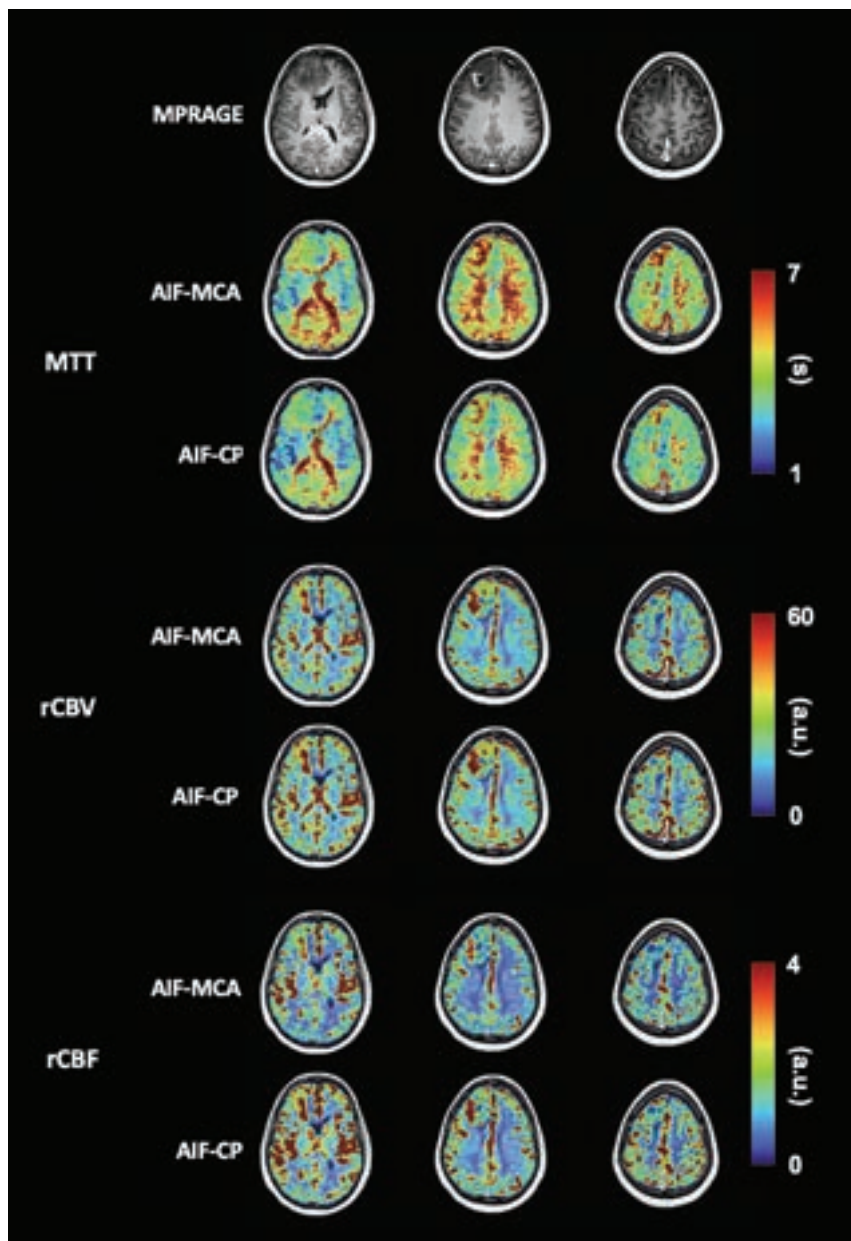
Perfusion maps calculated using an AIF selected from both the MCA and the CP for a patient with a right frontal high-grade glioblastoma. Also shown are the patient's T1-weighted MPRAGE images. Note that leakage correction was not used.
